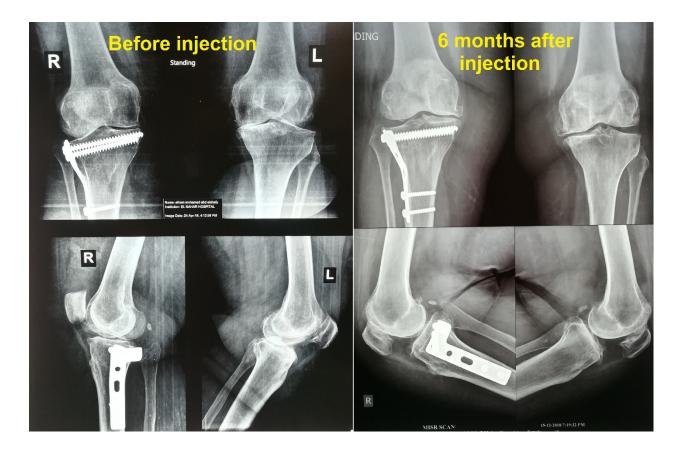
Antero-posterior erect x-ray view of both knees. A: before injection; B: 6 months after nonionised electromagnetic waves' enhanced autogenous adipose tissue & platelet rich plasma injection
